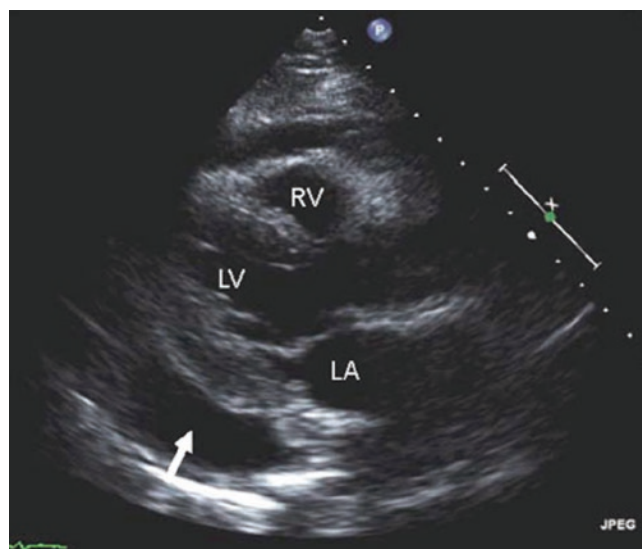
Case Study 2. Echocardiogram demonstrating a large pericardial effusion (white arrow). LA left atrium, LV left ventricle, RV right ventricle
